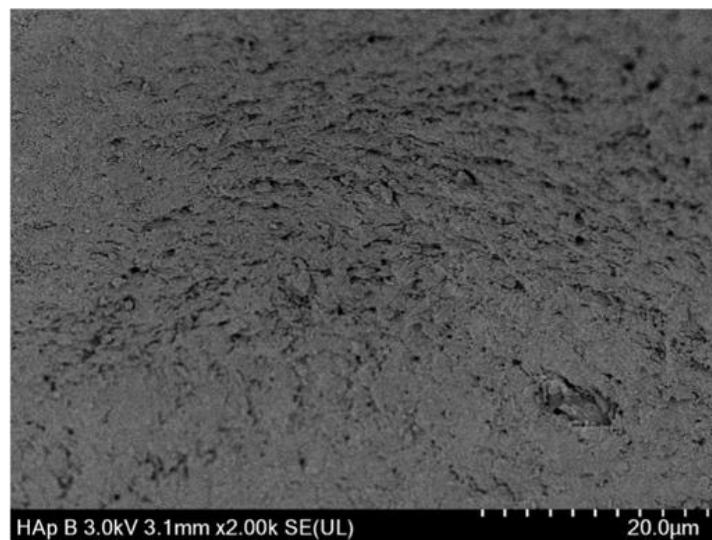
Ultrasound + Prophylactic Paste Group.
